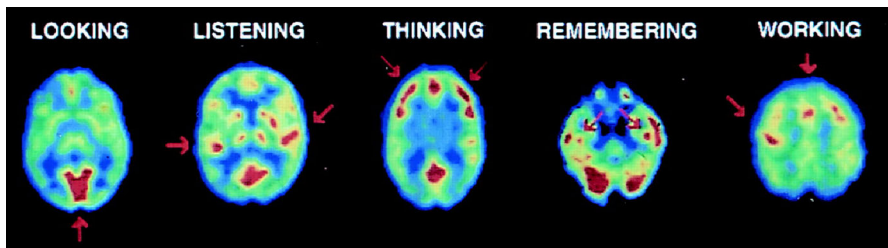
PET studies of glucose metabolism (by means of ^{18}F FDG) to map the human brain's response in performing different tasks. From Left to right:(LOOKING) Subjects looking at a visual scene activated visual cortex; (LISTENING) Listening to a mystery story with language and music activated left and right auditory cortices; (THINKING) Counting backwards from 100 by sevens activated frontal cortex; (REMEMBERING) Recalling previously learned objects activated hippocampus bilaterally; (WORKING) Touching thumb to fingers of right hand activated left motor cortex and supplementary motor system. Images are transaxial cross-sections of the brain with the front at the top. The highest metabolic rates are in red, with lower values from yellow to blue. (Courtesy of Drs. Michael Phelps & John Mazziotta, UCLA School of Medicine, 2015)
